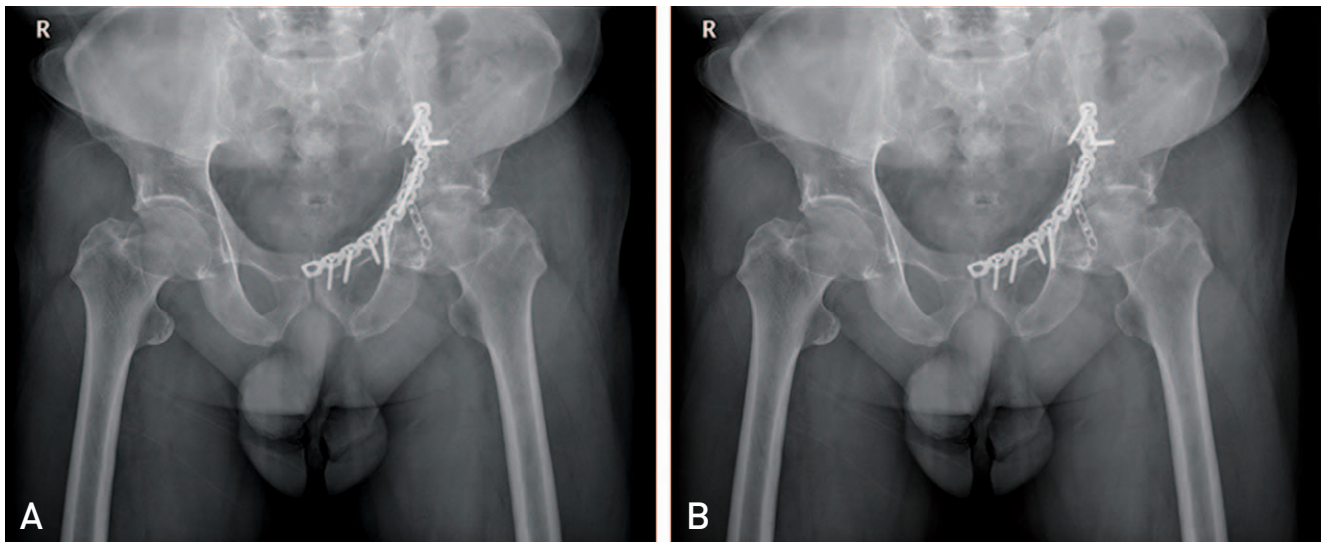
Postoperative images. (A) X-ray image of immediately after surgery. (B) X-ray image after 10 months.
